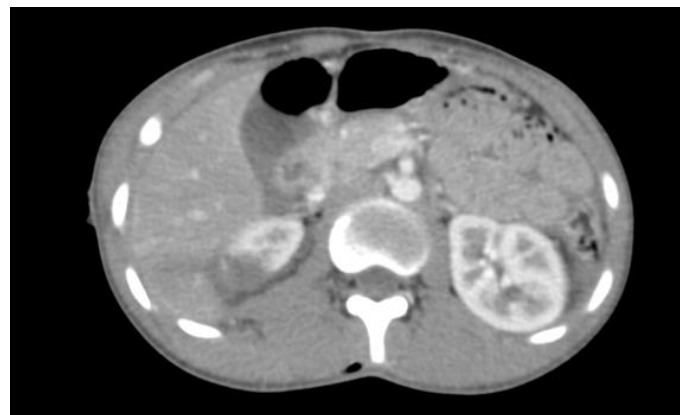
A 41-year-old male who had a blunt abdominal trauma underwent a CT scan. It shows a wedge-shaped hypodense area in the interpolar region of right kidney consistent with AAST Grade III renal injury.
